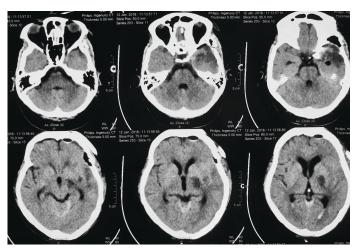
A re-evaluated CT (head) showed ischaemic changes, an infarct and surrounding edema at the posterior limb of the left internal capsule and basal ganglia area.
